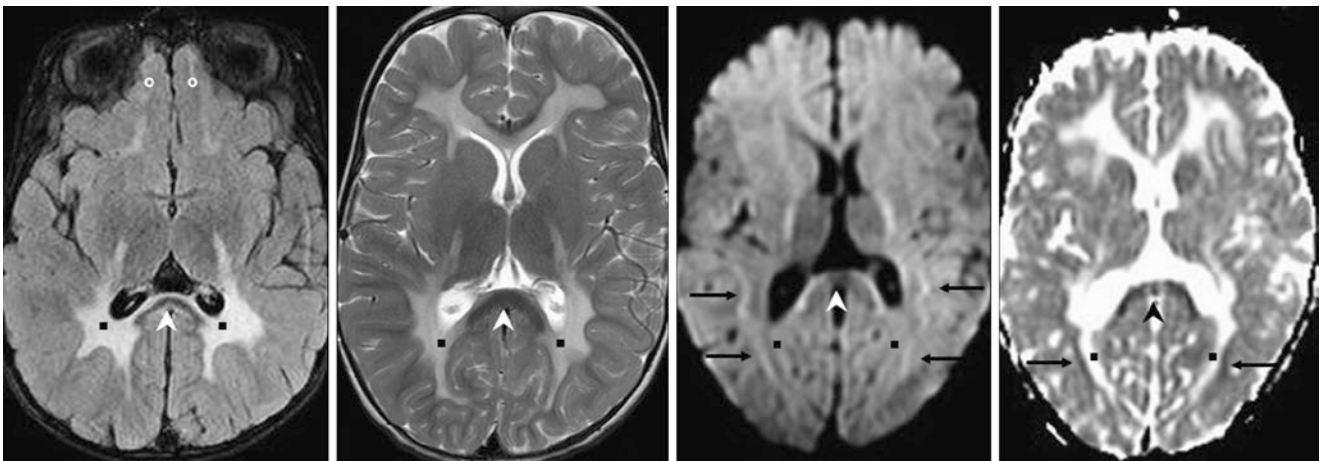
Comparison case of metachromatic leukodystrophy (MLD). A 22-month-old had a 1.5T MRI that showed signal abnormalities of peritrial WM (*squares*), OFWM (*circles*), and frontal PVWM on FLAIR (*left*) and T2WI (*left middle*), with sparing of the callosal
